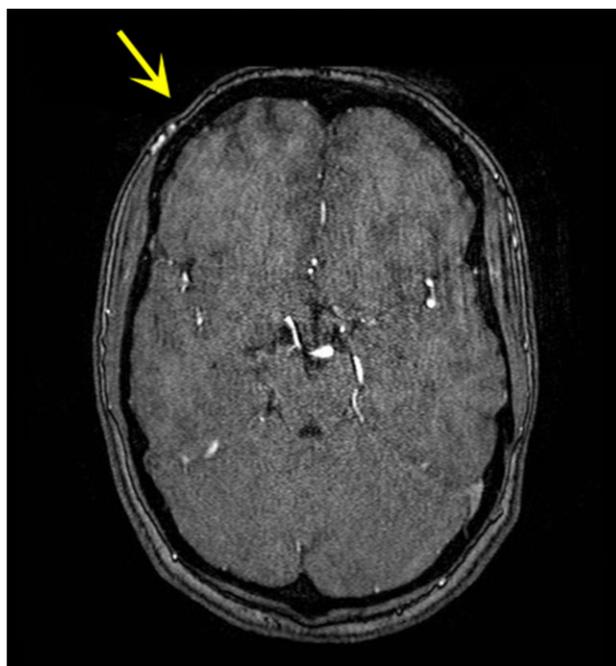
MRI 10 years after surgery showing right sided frontal subcutis atrophy.
